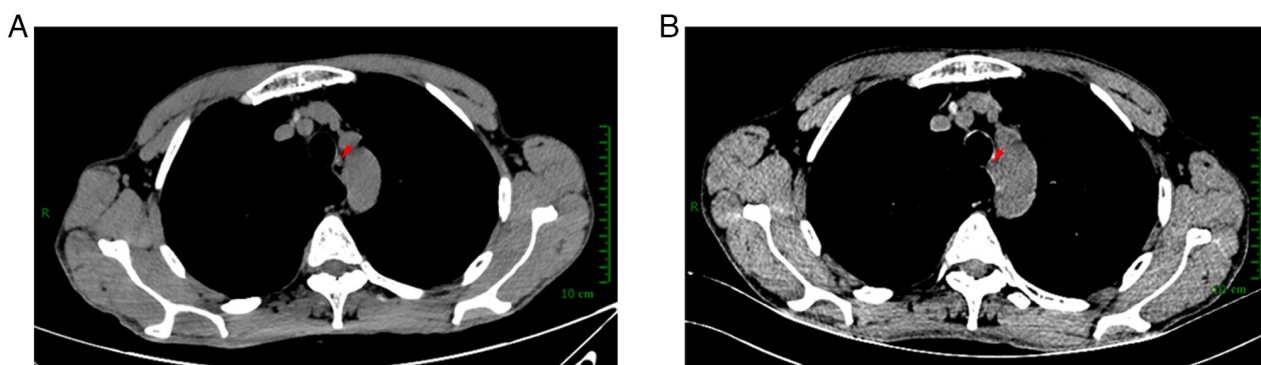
Contrast-enhanced CT results. (A) Pretreatment CT identified a mass within the esophagus (arrow) and suggested metastasis to the paraesophageal lymph nodes. (B) Post-treatment CT indicated a reduction in the lesion size (arrow). CT, computed tomography.
